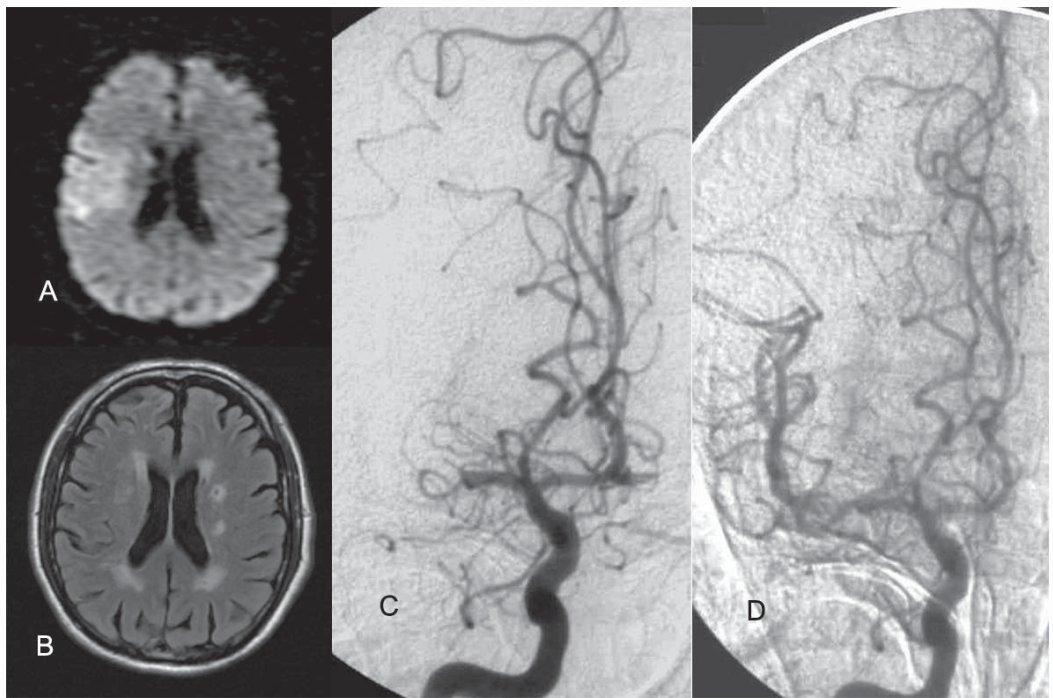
Intra-arterial thrombolysis in acute stroke. Diffusion weighted MRI performed 4 hours after onset of symptoms reveals restricted diffusion in the right periventricular region (A), though FLAIR study (B) does not reveal any abnormality. Angiogram reveals right middle cerebral artery occlusion (C), that was recanalized using intraarterial urokinase infusion (D).
